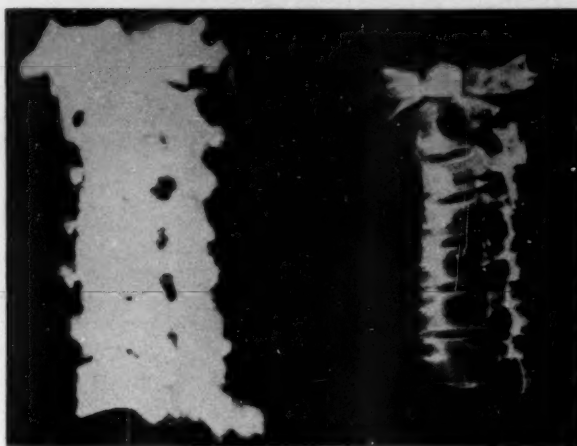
Post-mortem radiograph of the cervical spine from a case of fluorosis compared with a normal cervical spine. Note the marked osteosclerosis and osteophytosis, with narrowing of the intervertebral foramina
